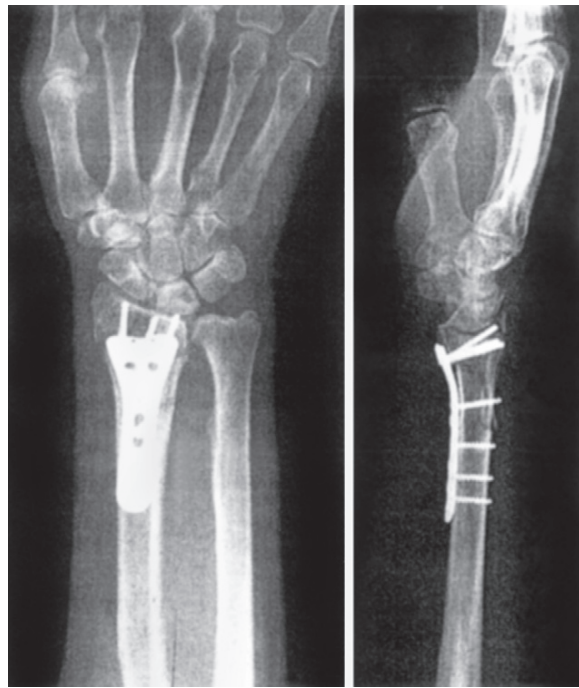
Posteroanterior and lateral radiographs demonstrating the anatomic reduction with a volar plate. The amount of peg protrusion over the dorsal cortex should be <1 mm. (Reprinted with permission from Chung K. Treatment of unstable distal radial fractures with the volar locking plating system. *J Bone Joint Surg* 2007;89 Suppl 2: 256-66, Figs. 12B, 12C.)
